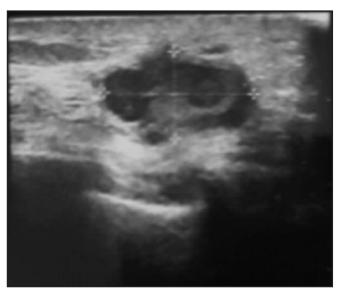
Ultrasound image of the left breast lump.
